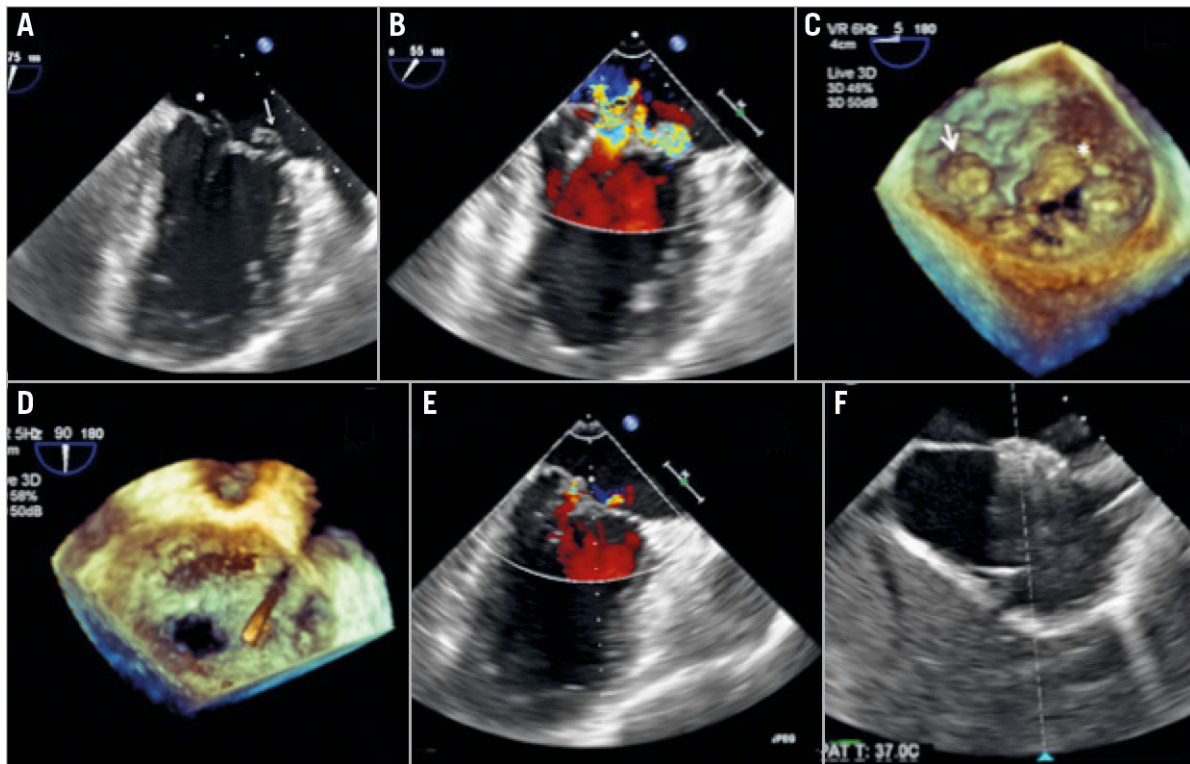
Transoesophageal echocardiography images during the MitraClip procedure. A) Bi-commissural view of the transoesophageal echocardiogram demonstrating the complexity of the Barlow's mitral valve. Arrow marks the medial A3 flail segment and the asterisk marks the P1 prolapse segment of the mitral valve. B) Bi-commissural view with colour Doppler demonstrating the significant mitral regurgitation arising from both the lateral and the medial site of the mitral valve. C) Three-dimensional en face view elucidating the complexity of the Barlow's mitral valve. Arrow marks the medial A3 flail segment and the asterisk marks the P1 prolapse segment of the mitral valve. D) Three-dimensional en face view demonstrating a total of three clips successfully implanted. E) Bi-commissural view of the transoesophageal echocardiogram showing only trivial mitral regurgitation after the procedure. F) The iatrogenic atrial septal defect was closed by an AMPLATZER atrial septal defect occluder.
